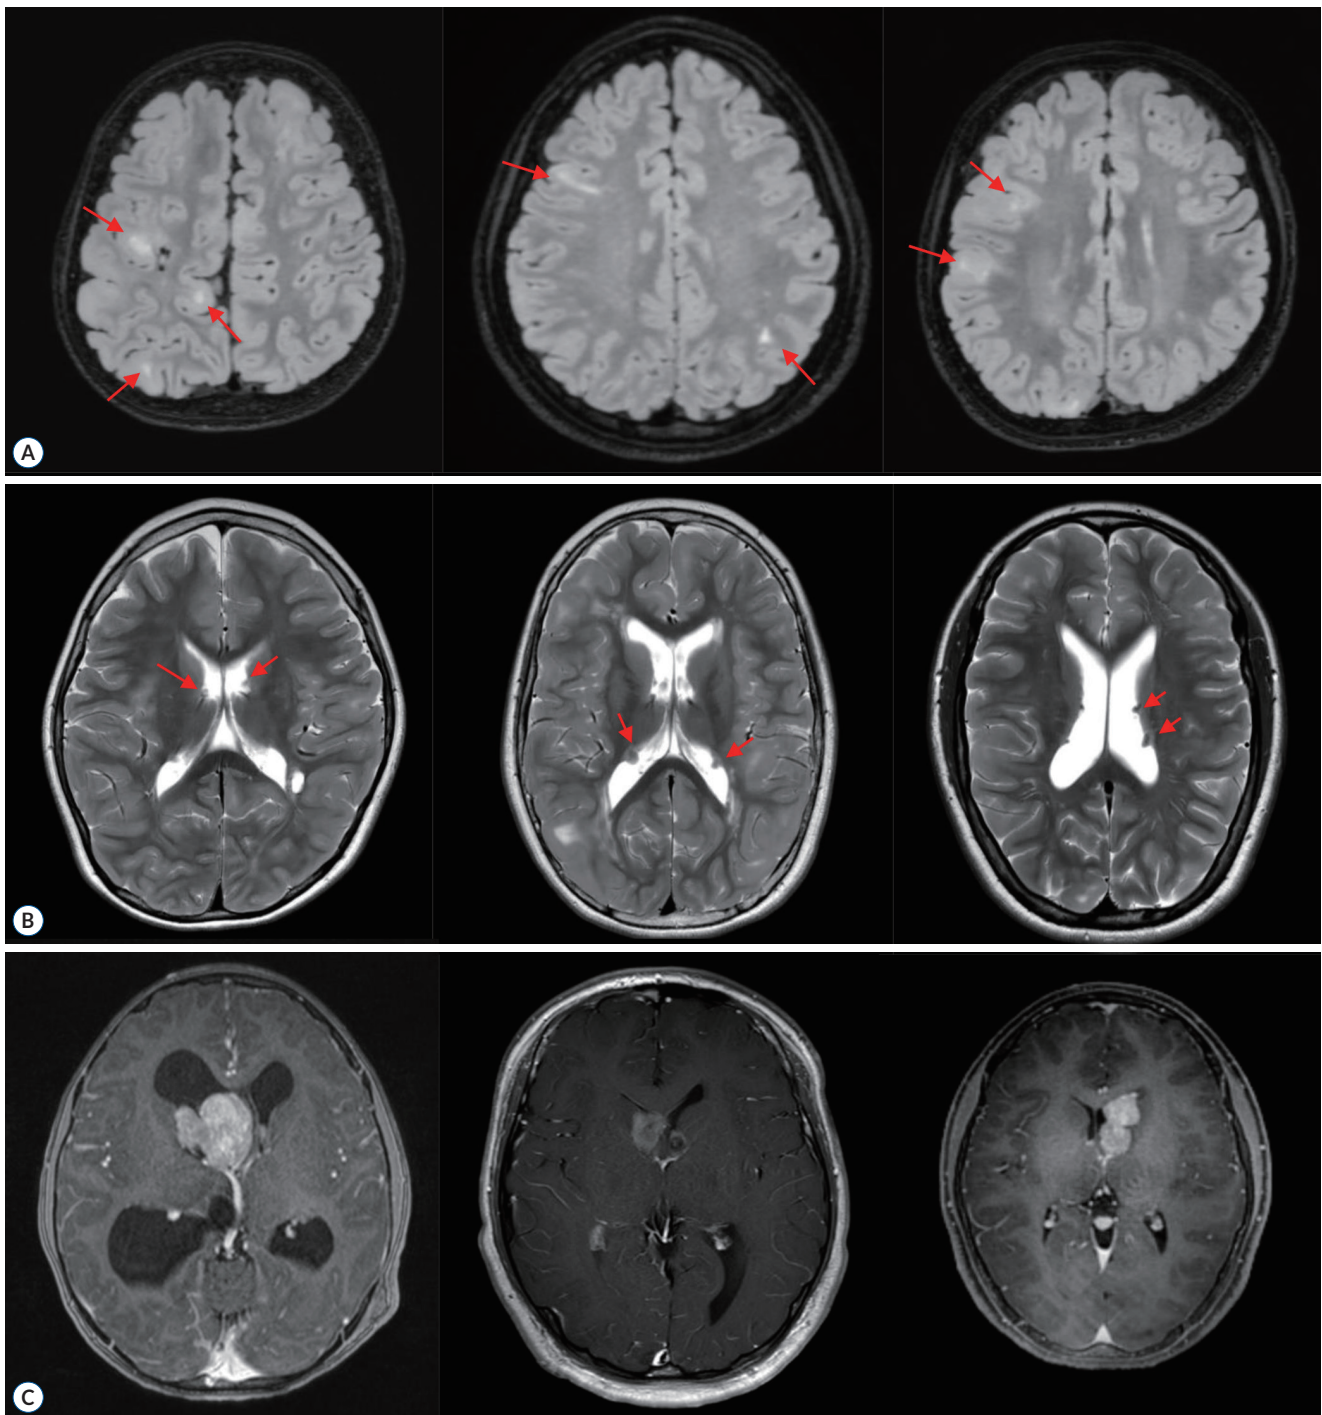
Typical brain manifestations in TSC. A : T2-FLAIR MRI showing cortical tubers as hyperintense lesions within the cerebral cortex (arrows). B : T2-weighted MRI indicating a subependymal nodule along the lateral ventricles (arrows). C : Contrast enhanced T1-weighted MRI demonstrating a well-circumscribed, enhancing mass near the foramen of Monro, characteristic of subependymal giant cell astrocytoma. TSC : tuberous sclerosis complex, FLAIR : fluid-attenuated inversion recovery, MRI : magnetic resonance imaging.
